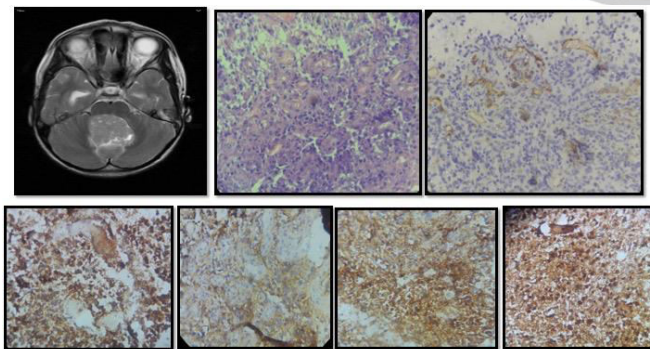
Ependymoma- A) MRI showing space occupying lesion in cerebellar vermis. B) H& E Section shows perivascular pseudorosettes. On IHC positive for C) CD31 around vessel wall. D) GFAP E) EMA F) CD99 G) S100
